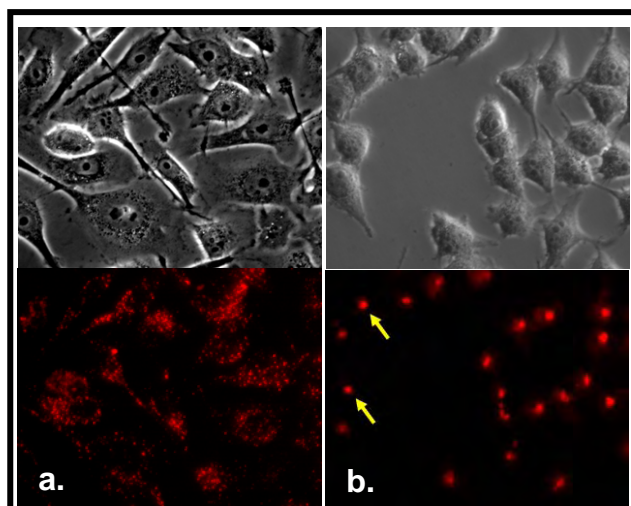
Differential intracellular sorting of quantum dots in PSMA non-expressing PC3 (a) and PSMA-expressing PC3-PSMA prostate cancer cells.
